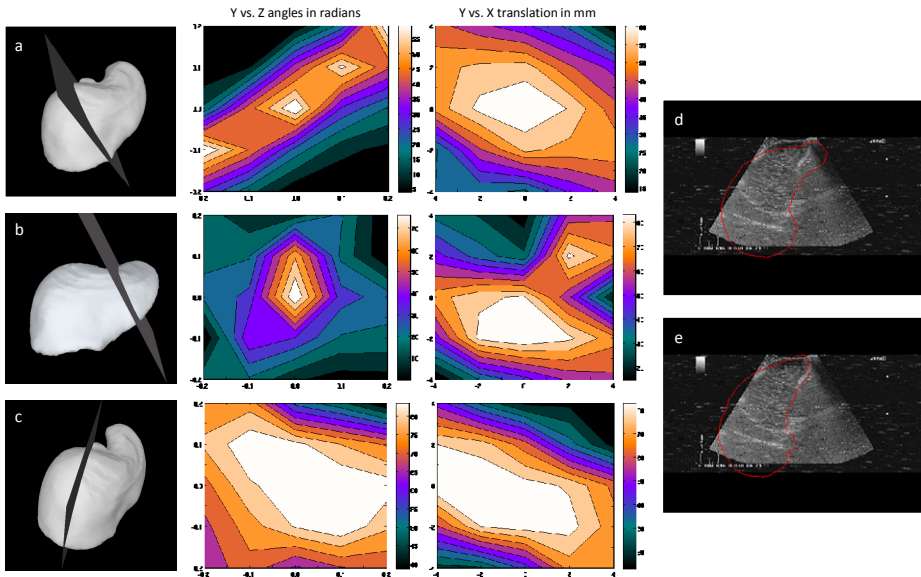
(a, b, c) The Instantiation Index for the scan plane at three locations with respect to the silicone liver model. Optimisation for respiratory position 1 with the Aloka ultrasound image with (d) the initial contour and (e) the optimised contour with the first scan plane (a) as the optimised scan plane.
